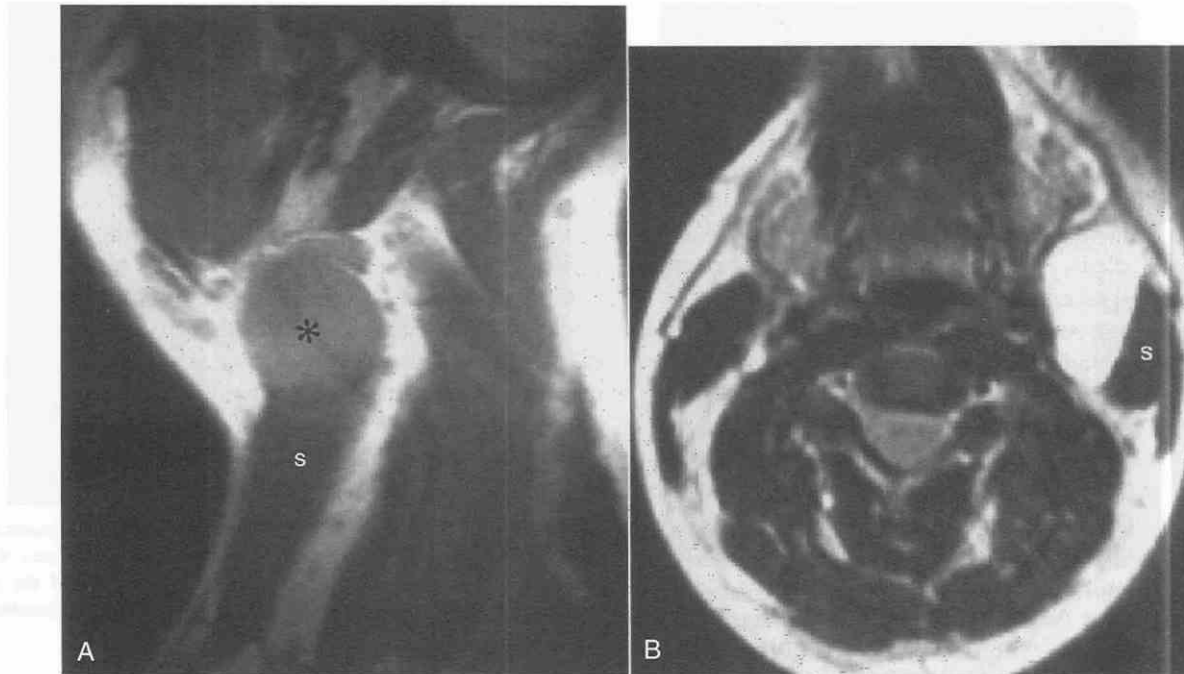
Type II second branchial cyst. A, Sagittal T1-weighted MR image demonstrates a well-circumscribed anterior triangle mass (asterisk) mildly hyperintense to muscle along the anterior margin of the sternocleidomastoid muscle (s). B, Axial T2-weighted MR image demonstrates a hyperintense mass along the anterior margin of the left sternocleidomastoid muscle (s). Compare with Figure 17-18.
